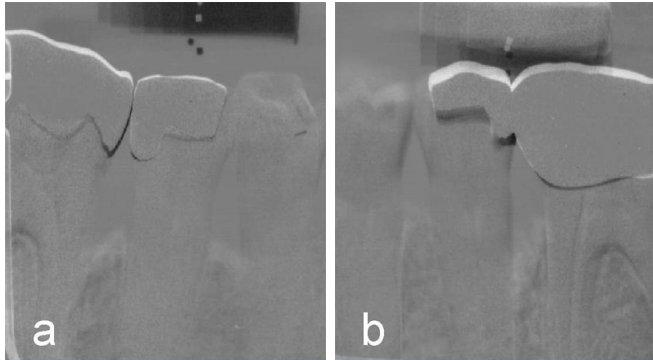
a+b: Subtraction image of baseline and 60 months radiographics of patient #7 showing bony fill at the distal aspects of tooth 44 (a) and 35 (b)
